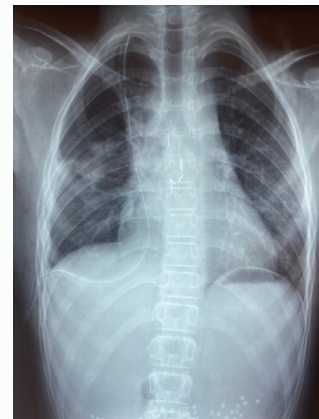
Postoperative chest X-ray: chest drain and radiopaque clips in place.
